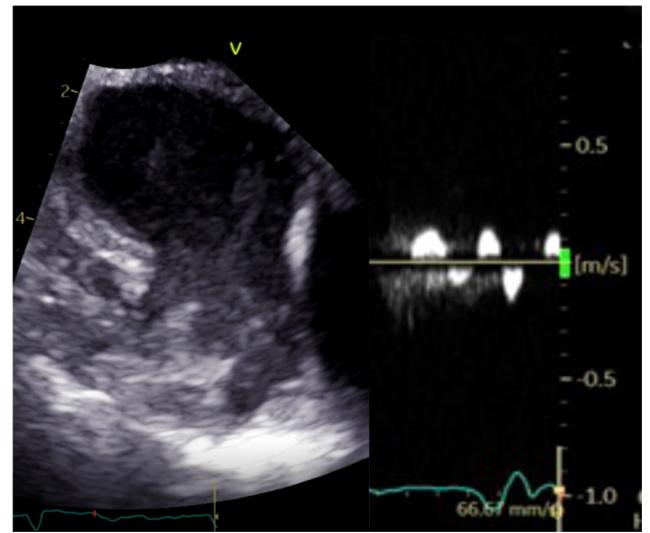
Dense spontaneous echo contrast in the left atrial appendage with markedly decreased flow velocities by pulsed-wave Doppler.
